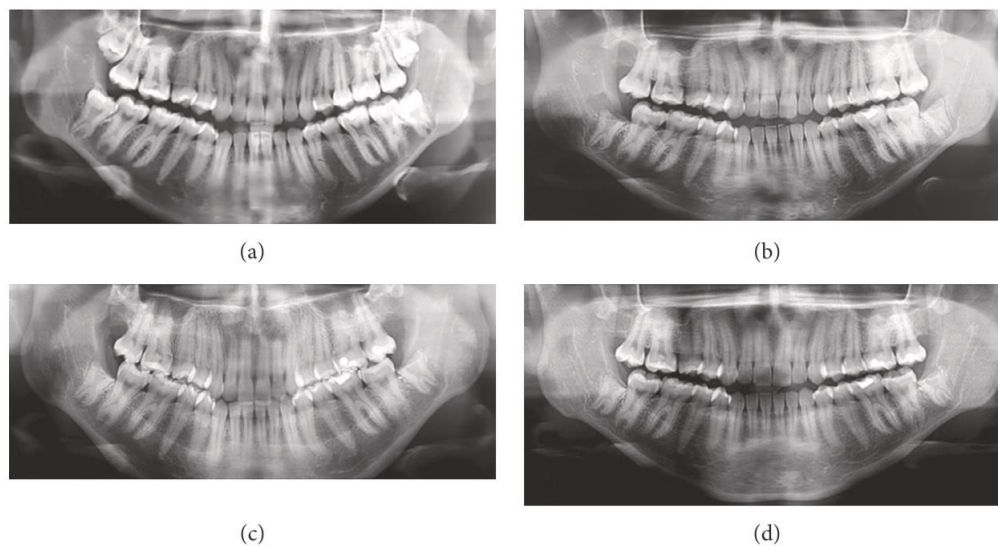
(a) Initial panoramic radiograph and (b–d) follow-up with 7 days, 6, and 12 months, respectively (Mendes *et al.*, 2018).
